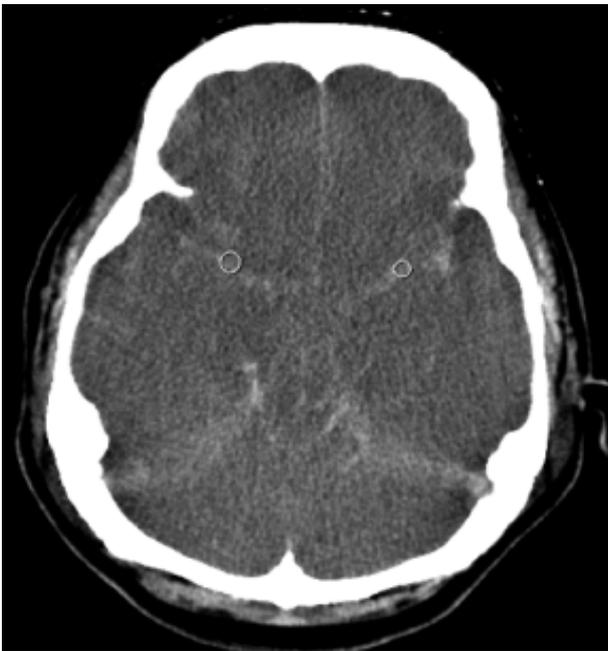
Areas where CT values (HU) were measured. CT values of high-density areas in the Sylvian vallicula/fissure were measured bilaterally on every side where HDAs first appeared.
